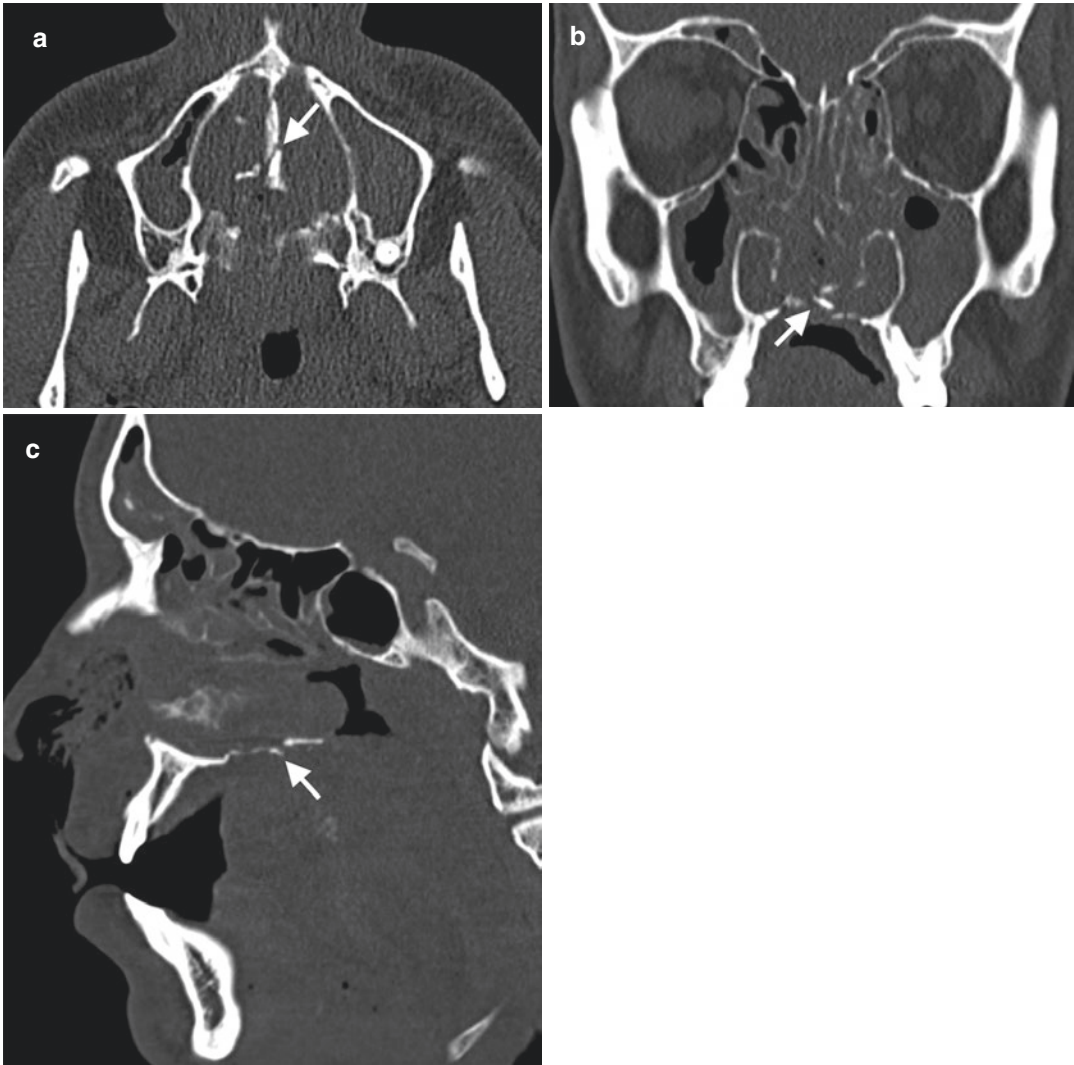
Palatine bone fracture. Axial (a), coronal (b), and sagittal (c) CT images demonstrate displaced fracture (arrows) of the hard palate
